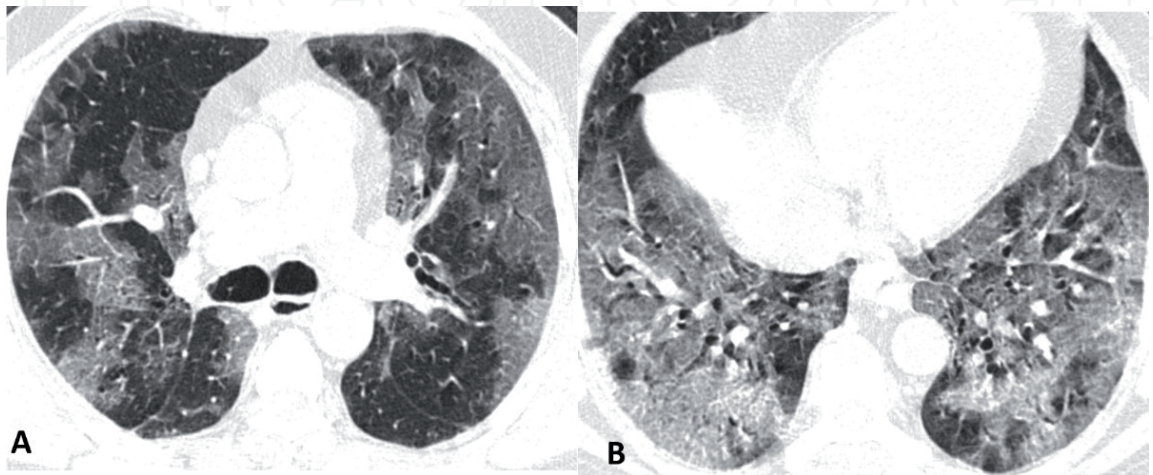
Axial chest CT images at slightly different levels (A, B) in lung window settings of a 56-year-old COVID-19 patient showing diffuse ground glass opacification in both lungs with a peripheral distribution.
